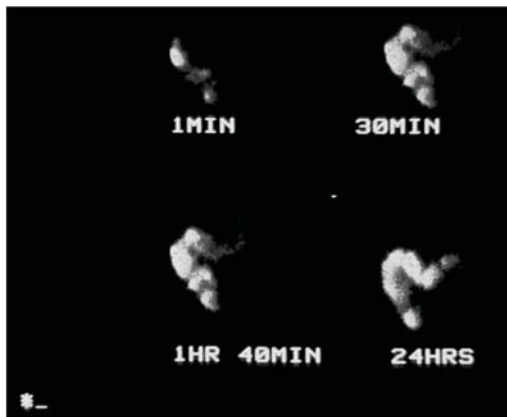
Radiolabeled scintigraphy scan demonstrating delay at splenic flexure after 24 hours. In normal subjects this would be in the rectum.
